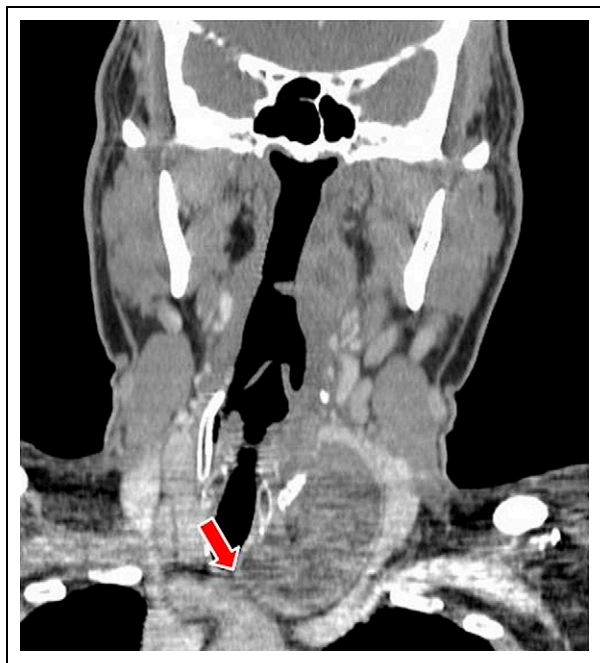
Type 4 branchial cleft cyst demonstrated on computed tomography coronal section. Note the close association of this lesion with the arch of the aorta.
